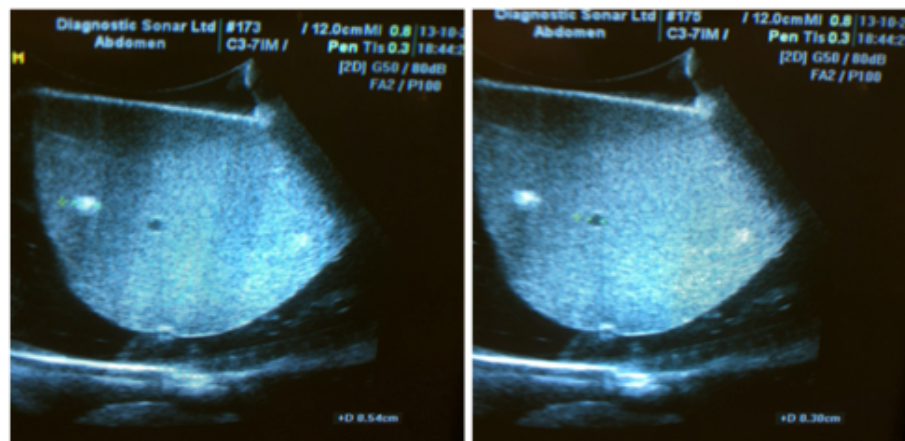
Solid masses (white) $\varnothing=0.54\text{cm}$ and cystic masses (black) $\varnothing=0.3\text{cm}$ as measured by the ultrasound ruler feature. Values shown on the bottom right corner of the images.
